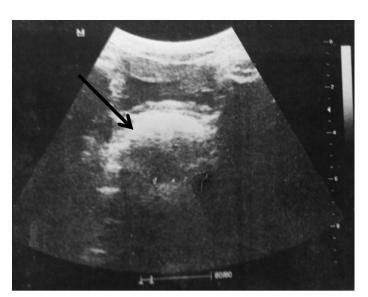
Abdominal ultrasound and Doppler US showed a huge distended gallbladder and biliary tract dilatation with biliary sludge.
